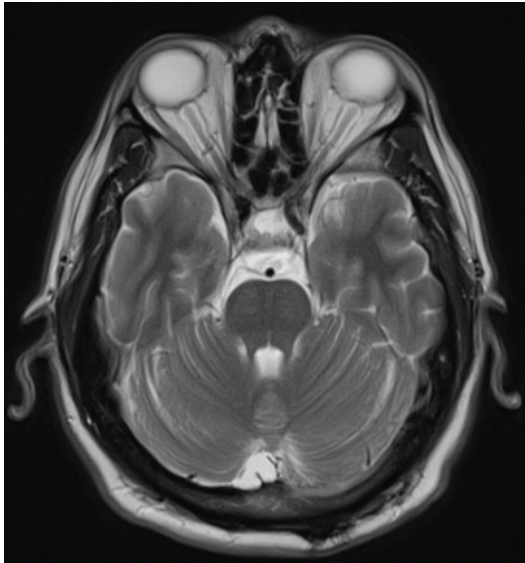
T-2 weighted axial MR image of patient 1 showing enlargement of the optic nerve sheaths and posterior scleral flattening on behalf of intracranial hypertension.
